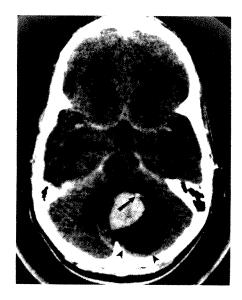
Contrast-enhanced axial CT scan shows cystic pilocytic astrocytoma of left medial cerebellar hemisphere. Noted are a small flecklike tumor calcification (arrow); a sharply demarcated, solid, enhancing component; and a macrocyst (arrowheads). Surrounding edema is minimal. Fourth ventricle is severely deformed with resultant obstructive hydrocephalus.
